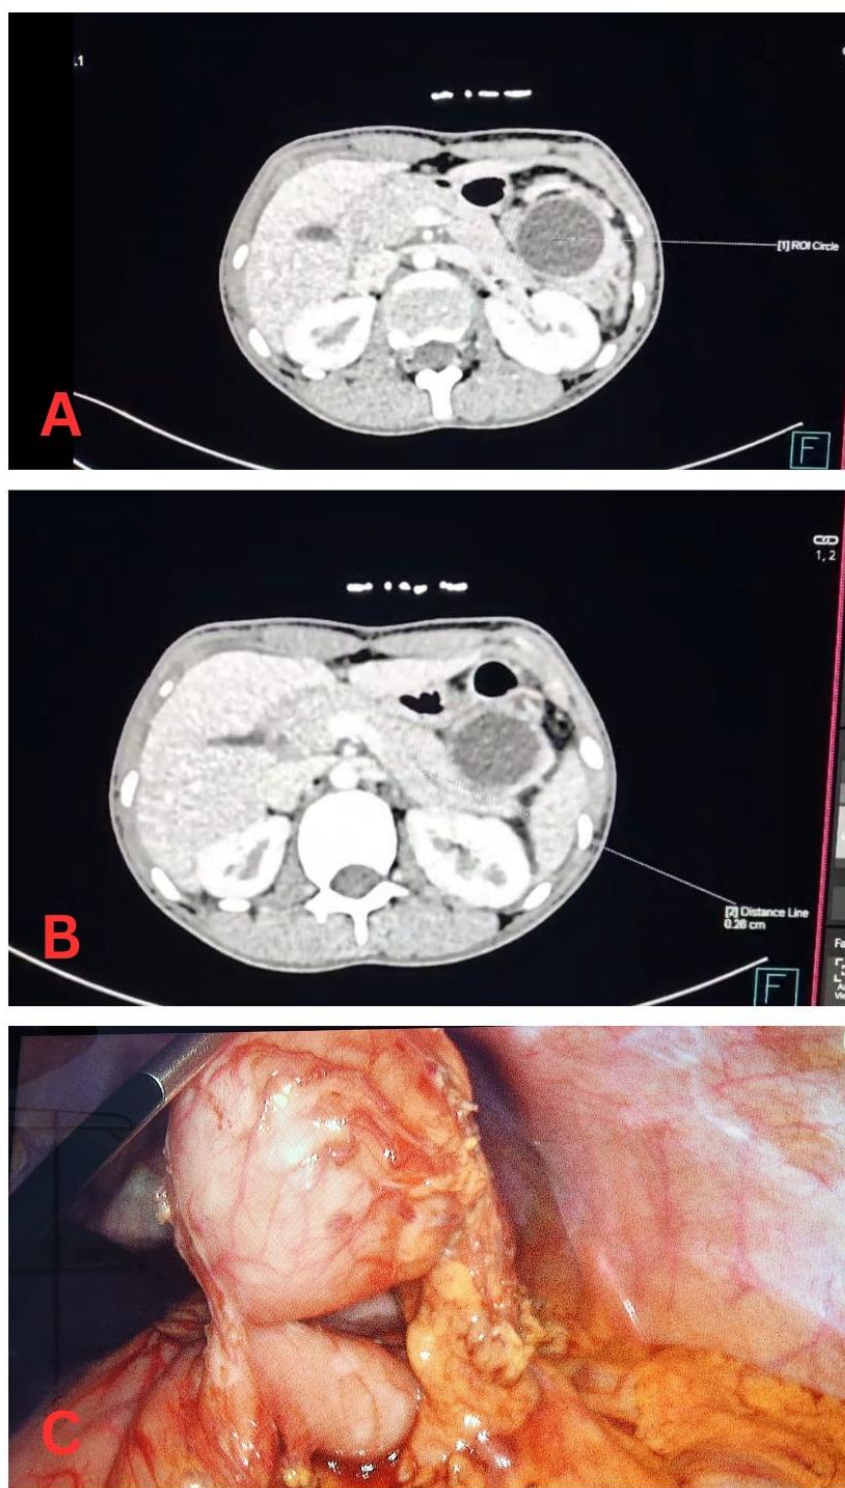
Pre-operative CT and laparoscopic view.
